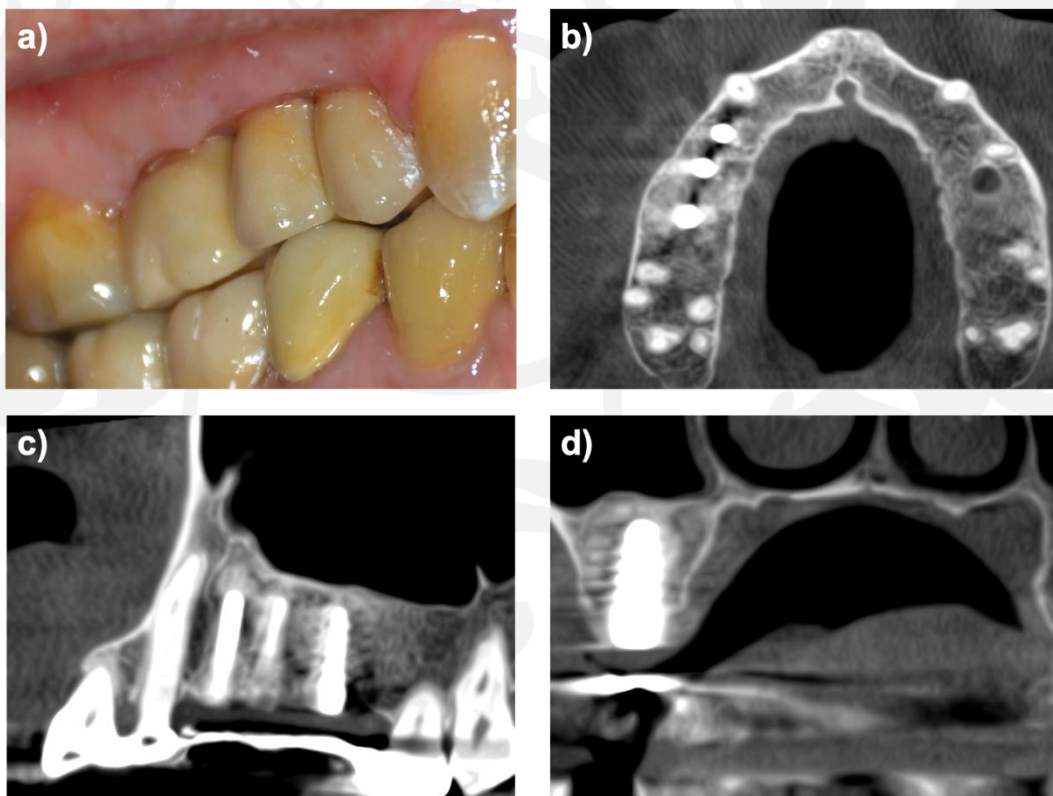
a) clinical view of the implant-based rehabilitation; b) c) d) 3D CBCT scan after implant placements.
